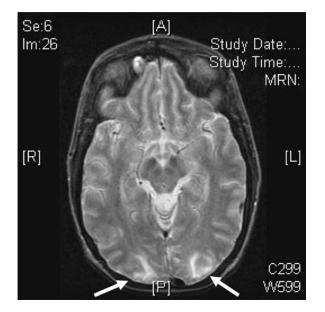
Posterior reversible encephalopathy syndrome in a bilateral lung transplant patient. A bilateral lung transplant recipient receiving tacrolimus therapy presented with headache, photophobia, and extremity weakness, which later progressed to seizures. Magnetic resonance imaging showed bilateral occipital lobe T2 hyperintensity (arrows.)
